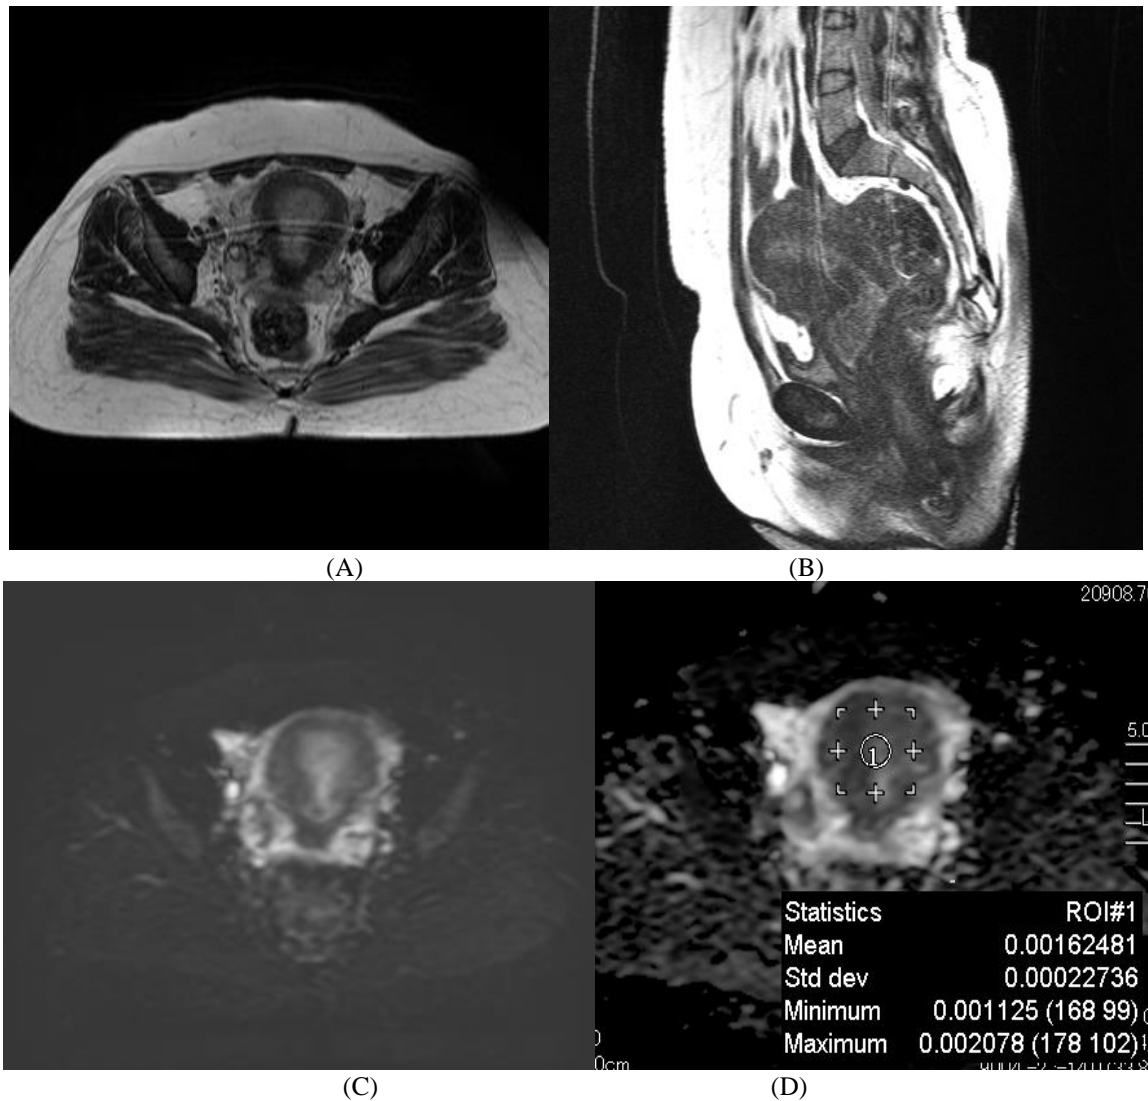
(A) and (B) sagittal and axial T2 WIs showing large endocervical mass distending the uterine cavity protruding through the cervix and displaying inhomogeneous hyperintense SI, (C) and (D) axial DWI and ADC WIs showing the mass displaying mixed hypo and hyperintense SI, (E) shows the ADC value of the lesion of about ( $1.3 \times 10^{-3} \text{ mm}^2/\text{s}$ ), pathologically proven to be disordered proliferative endometrium
